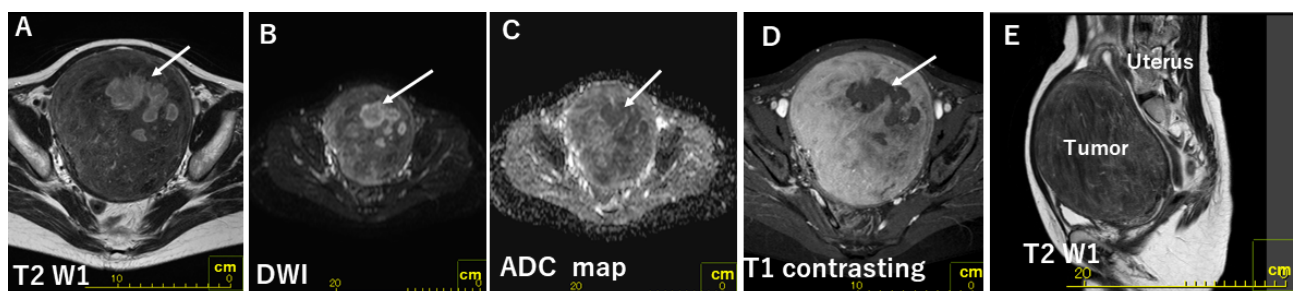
Preoperative magnetic resonance imaging showing a large tumor on the cervical anterior wall of the uterus. (A) Transaxial T2-weighted image. (B) Transaxial diffusion-weighted image. (C) Transaxial apparent diffusion coefficient (ADC) image. (D) Transaxial T1-weighted contrast-enhanced image. (E) Sagittal T2-weighted image. The tumor volume is  $16 \times 13 \times 13$  cm. The inside of the tumor shows a decreased intensity area of the T2 signal, which is a high intensity on diffusion-weighted imaging and low intensity on ADC and contrast-enhanced images (arrow).
